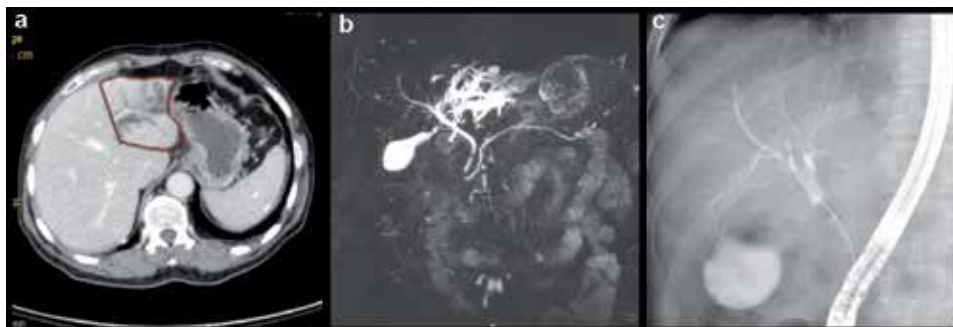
(a) Computed tomography scan (CT scan) of abdomen and pelvis; (b) magnetic resonance cholangiopancreatography (MRCP); (c) endoscopic retrograde cholangiopancreatography showing a focal dilation of the biliary tree to the left lobe through the suggestion of subtle ill-defined enhancing mass lesion at the level of liver hilum.
